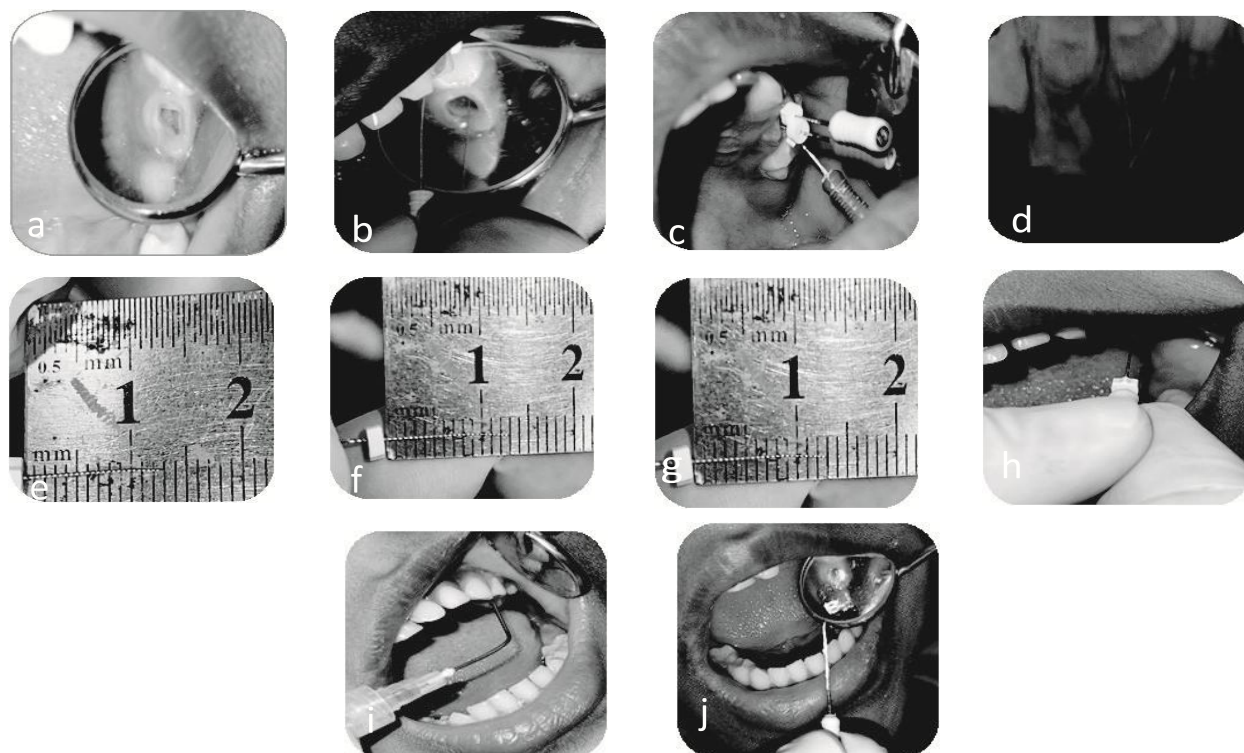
Operative procedures a) Access cavity preparation, b) Canal locating, c) Instruments Used for Working length determination. d) Diagnostic X-ray, e) Mesiobuccal: 13 mm, f) Distobuccal: $10+2=12$ mm g) Palatal: $12+0.5=12.5$ mm, h) Biomechanical preparation of the canal up-to file no 30, i) Irrigation of the canal is done with normal saline, j) After drying the canal, apply calcium hydroxide into the canal.
